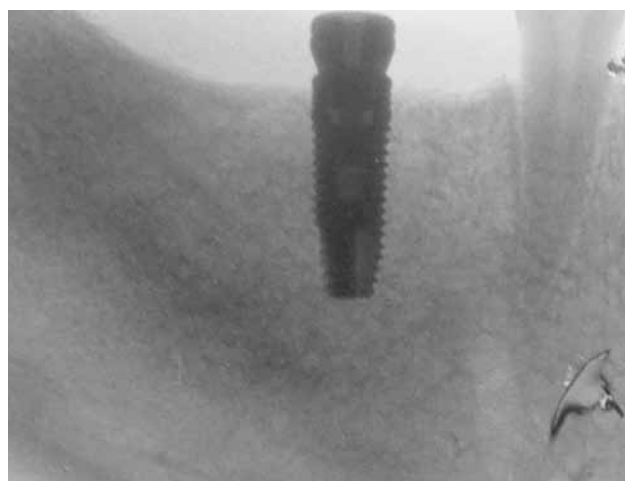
Postoperative IOPA X-ray
